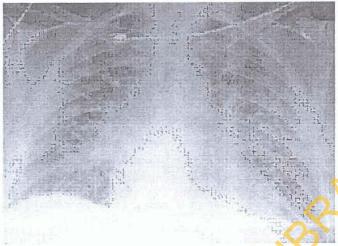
Postero-anterior chest radiograph showing alveolar infiltration that is more concentrated in the peri-hilar region. Notice how the streaky opacities fan out from the hilar region.
